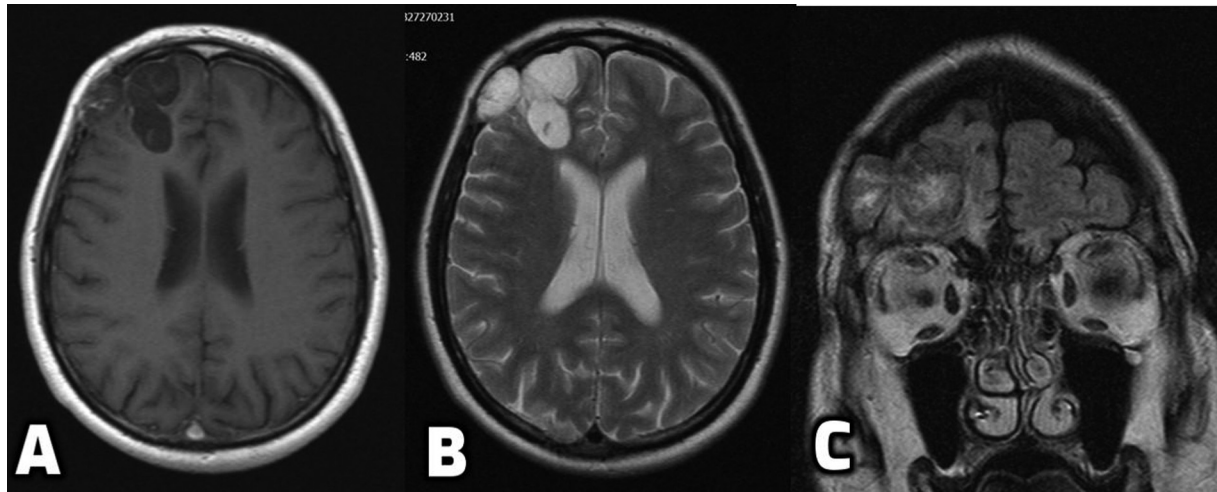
(A) T1-weighted axial magnetic resonance imaging (MRI) of the brain from 2008 showing the hypointense intra-axial plus extra-axial cystic lesion. (B) T2-weighted axial MRI of the brain from 2008 showing the homogenous hyperintense multilobulated lesion with septations within. (C) Fluid-attenuated inversion recovery (FLAIR) coronal MRI of the brain showing the frontal intradiploic extension of the lesion with no perilesional edema.
